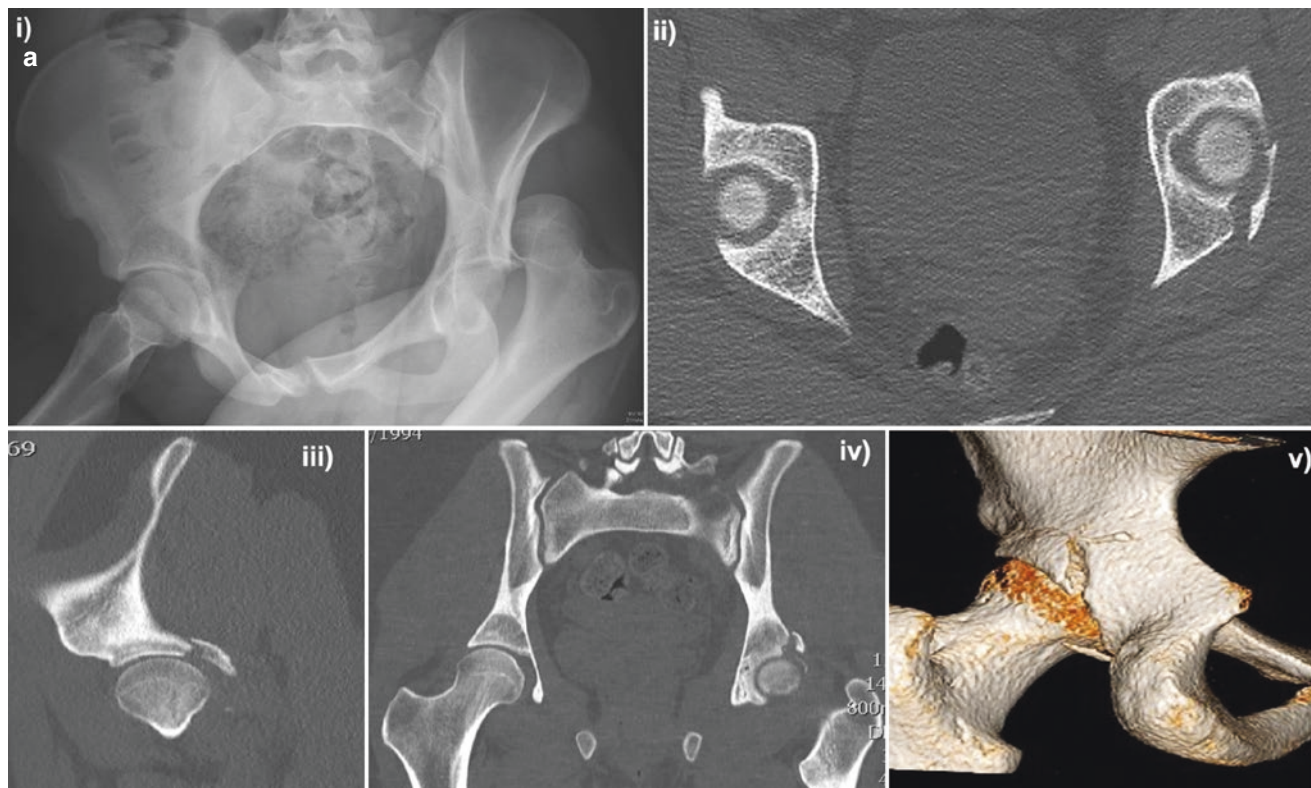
(a) (i) Antero-posterior radiograph in a 18 year old female American footballer who sustained a left hip fracture dislocation following a tackle. (ii) CT slice axial cut; (iii) CT slice sagittal cut; (iv) CT slice coronal cut; (v) 3D model left hip showing fracture of the posterior wall. (b) (i) intraoperative images of the left hip, which was approached using a Kocher-Langebeck incision showing a labral tear (white arrow); (ii) Labral tear was repaired with a mitek suture (white arrow); (iii)
